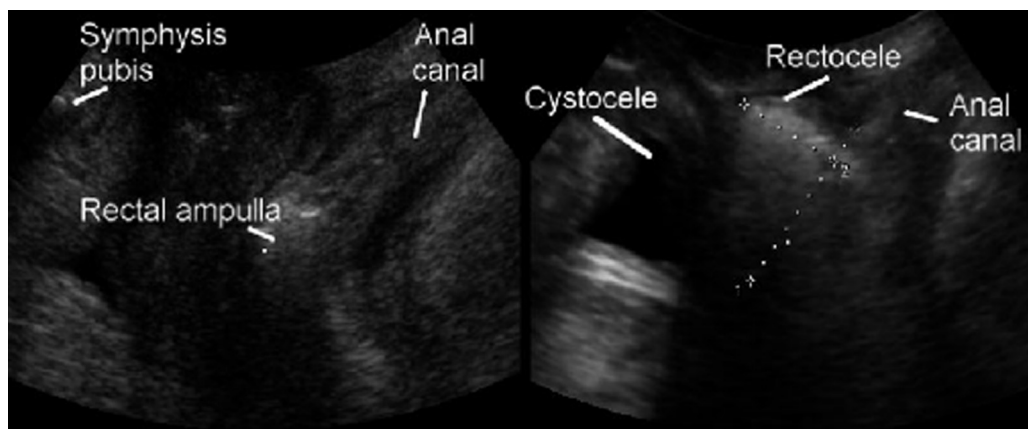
Quantification of a true rectocele on translabial ultrasound (mid-sagittal plane, with the transducer surface resting on the perineum). Measurements indicate width (3.3 cm) and depth (1.9 cm) of a true rectocele which is apparent as a discontinuity in the anorectal muscularis. Left image is at rest; right image is maximal Valsalva.
